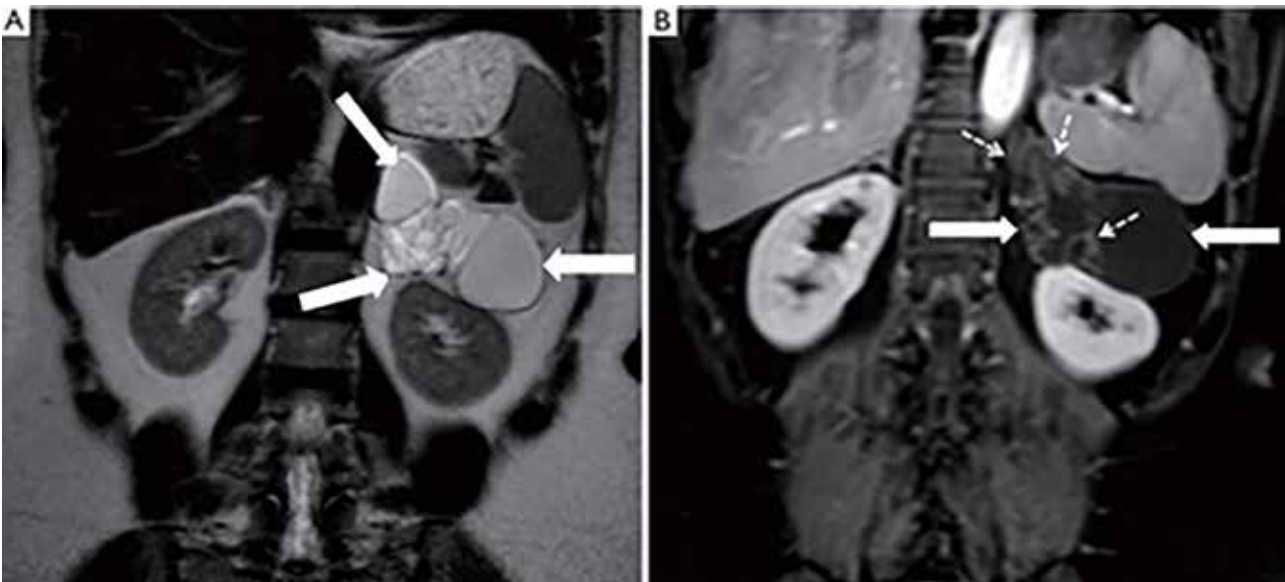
Coronal T2W MRI shows a multiloculated cystic mass (arrows) in the left adrenal gland (A). On contrast-enhanced fat-saturated T1W MRI, only enhancement of intratumoral septations (dashed arrows) is seen (B). Findings are characteristic of adrenal lymphangioma. (Secil M, Demir O, Yorukoglu K. MRI of adrenal lymphangioma: a case report. *Quant Imaging Med Surg* 2013; 3(6): 347-348)
